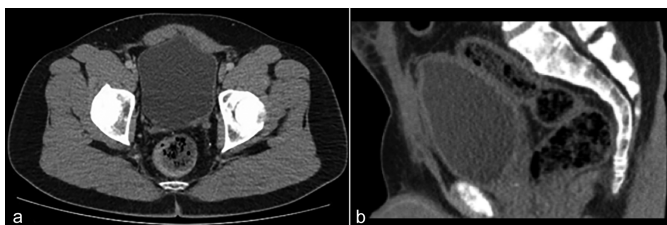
Postoperative Computed Tomography of the surgical area with no recurrence. (a) Transverse plane (b) Sagittal plane.
